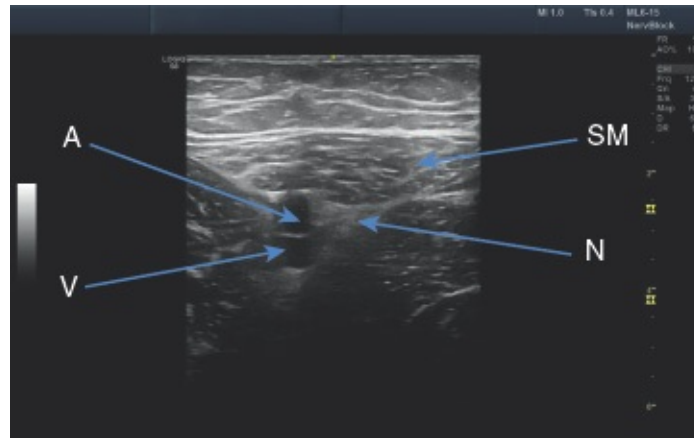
• Ultrasound image of adductor canal block. SN, saphenous nerve; SM, sartorius muscle; A, femoral artery; V, femoral vein.
